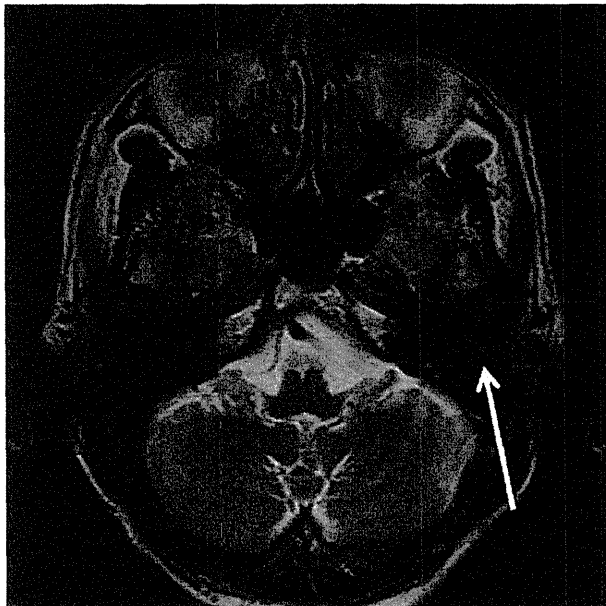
A 3-D T1-weighted image with 1.5 mm thickness. Cerumen impaction is shown on the left external auditory canal (arrow), visualized as a structure with high signal intensity.
